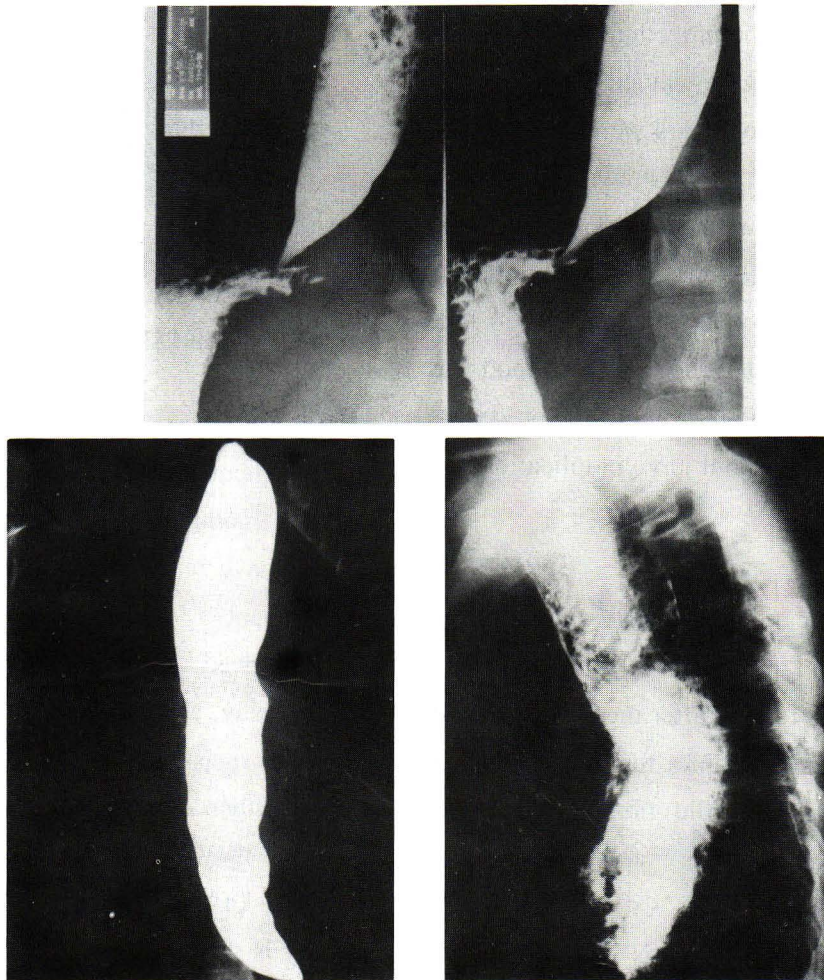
Radiographic finding before dilatation.
